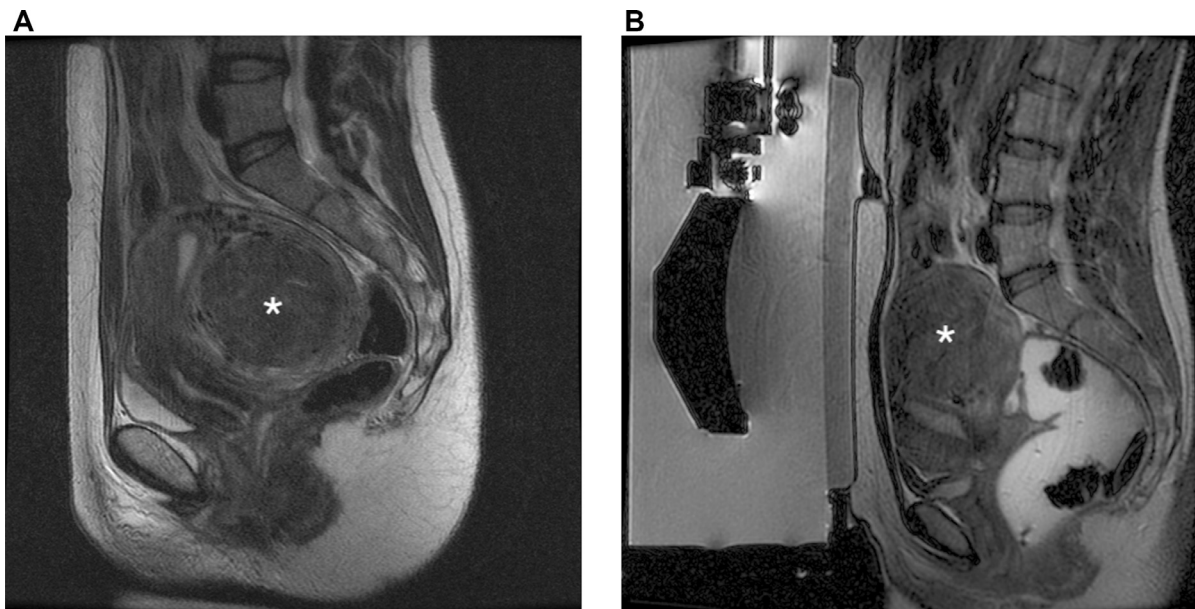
MR images of a patient with a 6 cm intramural uterine fibroid (white star in A and B). Pretreatment sagittal T2-weighted shows the presence of the uterine fibroma in the posterior wall of the uterus which is located close to the sacral bone (A). Rectal filling allows uterus to be displaced anteriorly, thus increasing the distance between the uterine wall and the sacral bone, as shown in the T2-weighted sagittal image (B).
